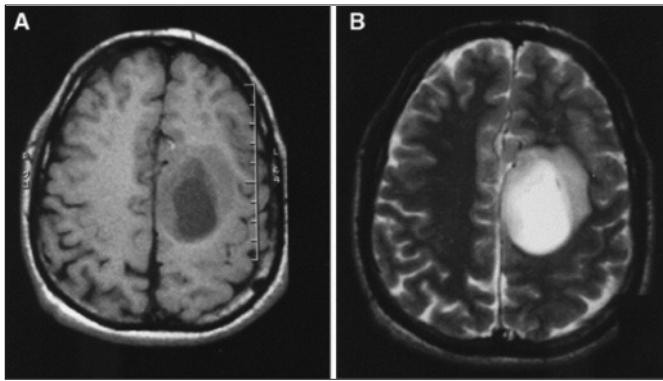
Axial MR images of a cystic tumor, found to be an anaplastic oligodendroglioma. (A) Unenhanced T1-weighted image, showing varying degrees of hypo intensity. (B) T2-weighted image showing hyper intensity, especially of the central cyst.
